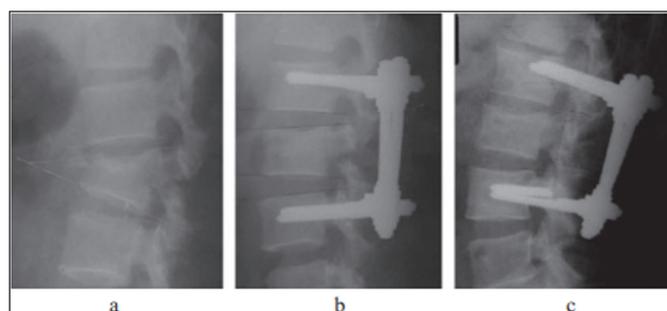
For a 51-year-old male with T12 burst fracture, PSSF was used for his treatment), post-operative radiograph (6 months) representing pedicle screws that were bent
